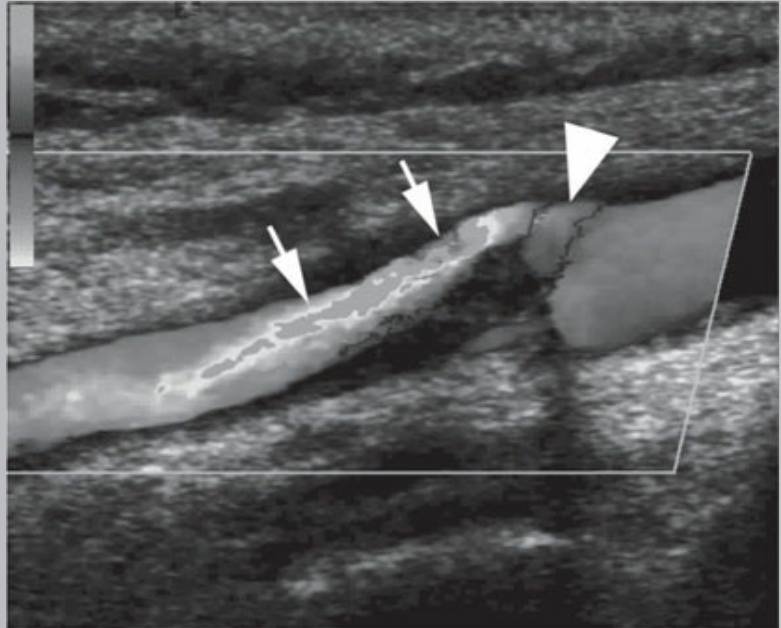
Color Doppler aliasing. The arrows demonstrate localized aliasing within a stenotic internal carotid artery. The arrowhead demonstrates a true reversal of flow. Color image provided online.
